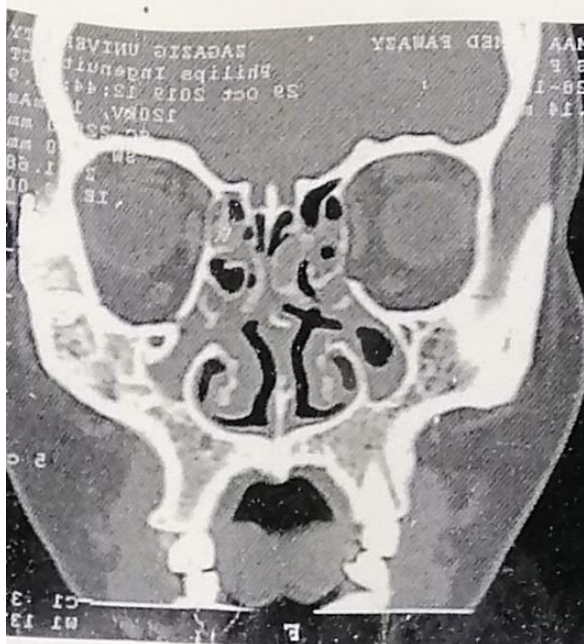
CT nose paranasal sinus coronal view shows paranasal sinus opacity.
